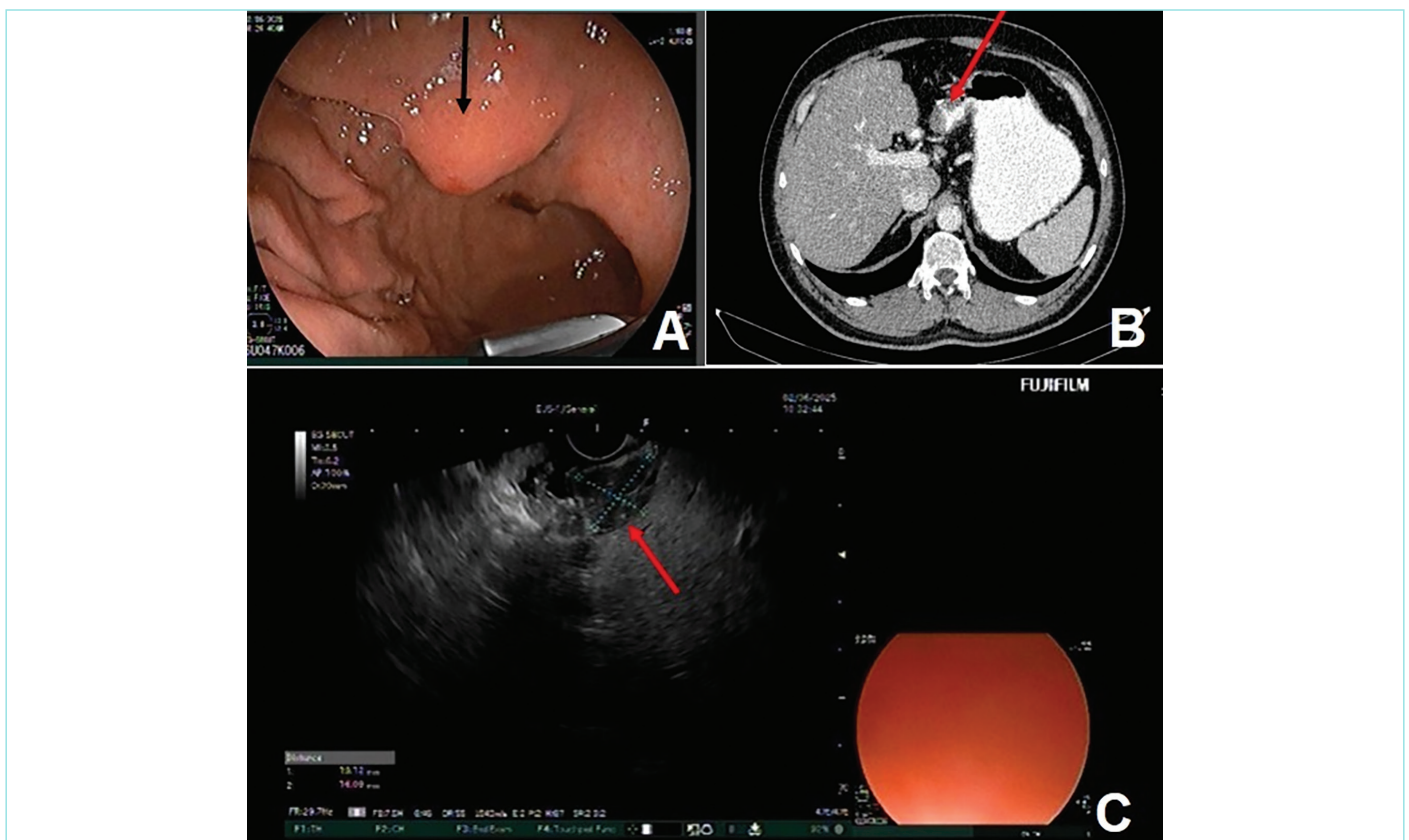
Images of HP in the stomach antrum. A. Mucosal bulging associated with a submucosal mass on endoscopy. B. Submucosal mass in the stomach antrum on abdominal CT. C. Origin of the lesion from the submucosal layer on endoscopic ultrasonography (EUS).
